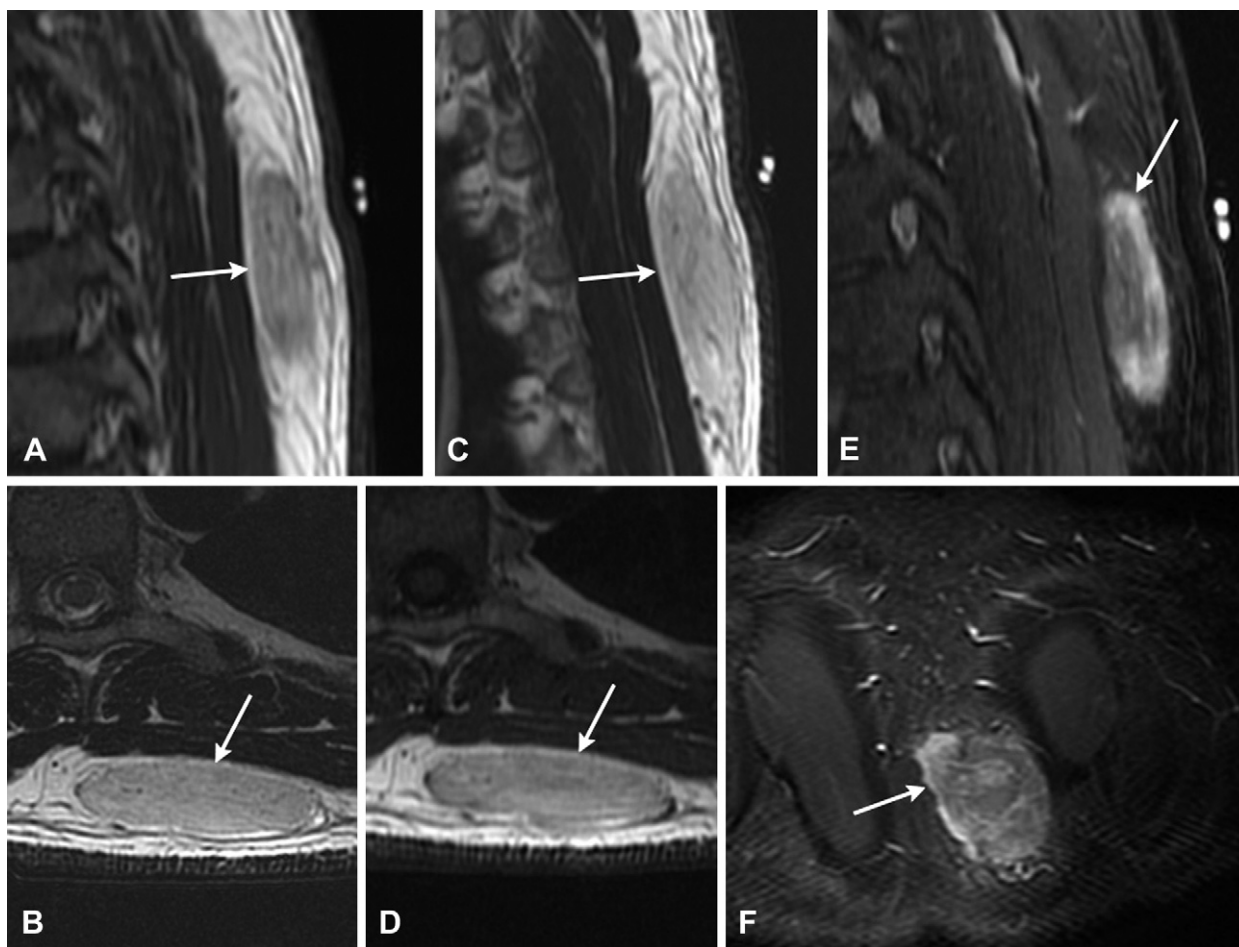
On magnetic resonance imaging, there was one well-circumscribed septate mass (arrows) with intermediate signal intensity on the sagittal (A) and axial (B) T2-weighted images and the sagittal (C) and axial (D) T1-weighted images. On T2 fat saturation (E) and short T1 inversion recovery (F) images, the mass demonstrated uneven signal loss with an irregular peripheral high signal change. There was a clear fatty strap between the lesion and the underlying musculature.
